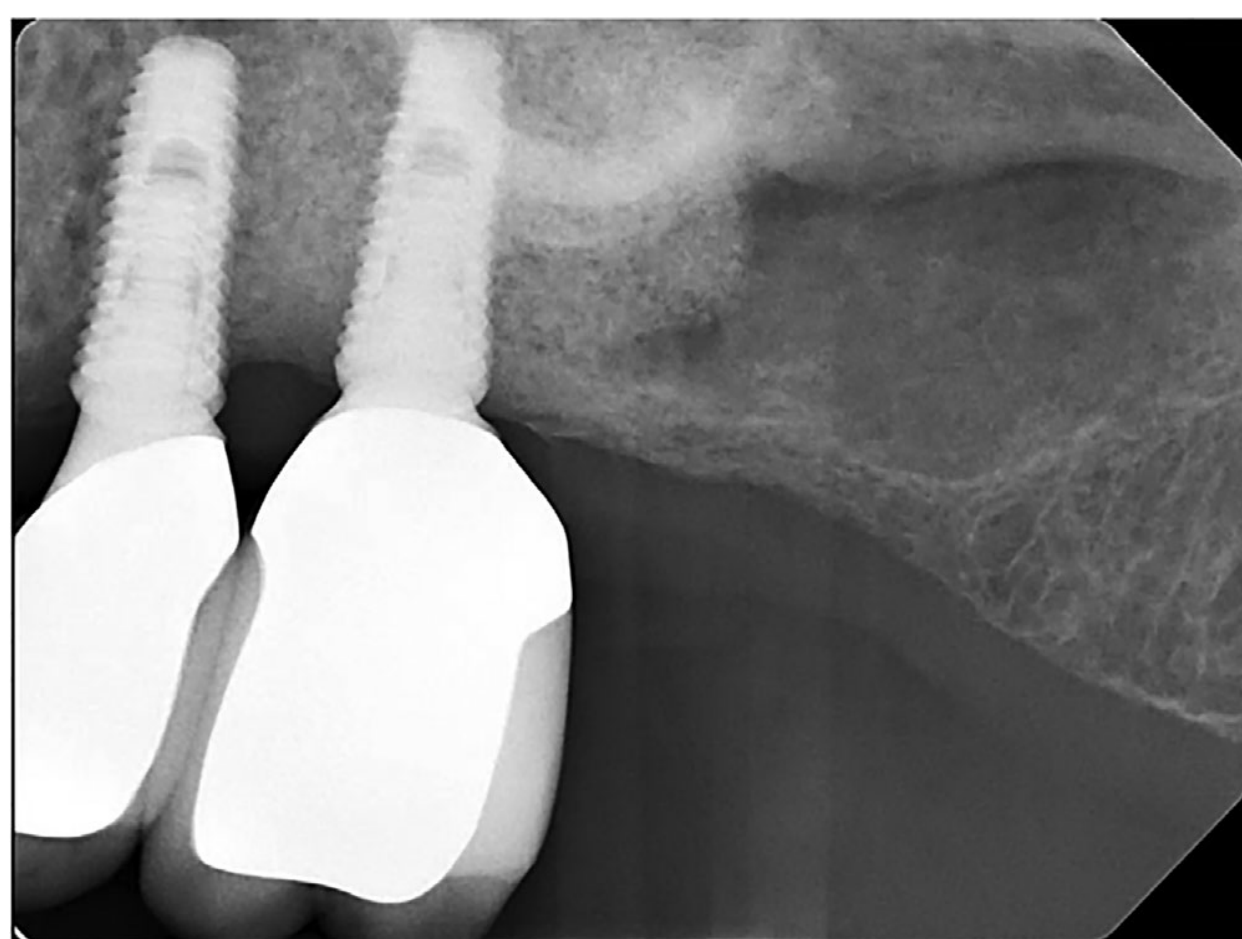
Postoperative periapical radiograph of implant placement and loading at #13 and #14.
